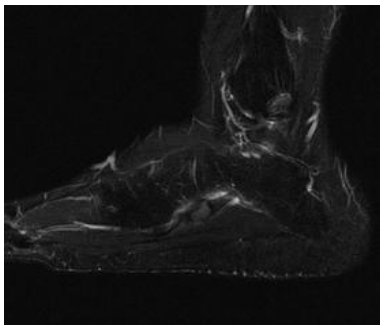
Lateral MRI of left foot showing the retraction of os peroneum.
